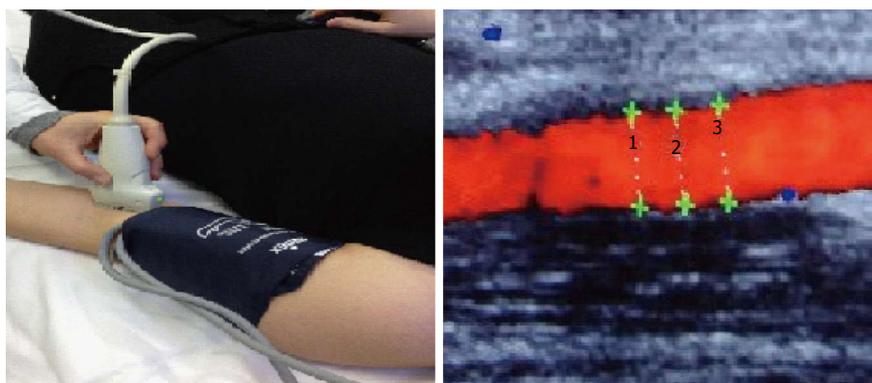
Flow mediated dilatation is based on the reactive phenomenon that occurs when arterial blood flow is restored after a period of transient arterial occlusion using a sphygmomanometer. This reactive hyperaemia is observable at ultrasound power Doppler mode monitor.
